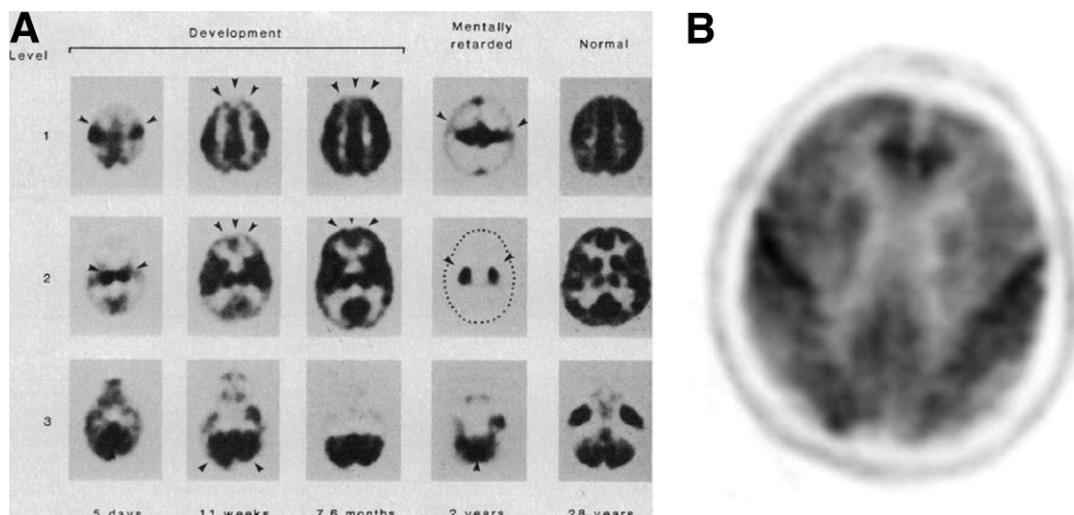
Glucose utilization in infants with increasing age using FDG-PET imaging (A). In infants at age 5 days, highest glucose metabolism is seen in sensorimotor cortex, thalamus, midbrain, and vermis (arrows). By 3 months, activity increases in parietal, temporal, and occipital cortices (arrows) and basal ganglia with subsequent increase in frontal cortices and association cortices by 8 months (arrows). (Reprinted with permission from Chugani and Phelps.⁸⁷) Note preservation of glucose metabolism in sensory-motor cortex in patient with Alzheimer's disease (B) which mimics metabolic activity in infants up to 5 weeks of age.
